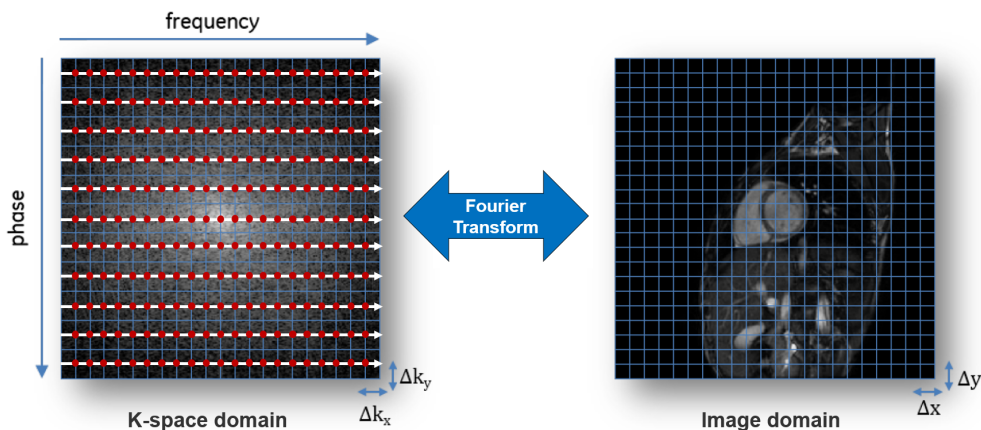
Data in k-space collected on a Cartesian grid (left) for cardiac MR imaging. The Fourier transform is used to transform the k-space samples to an image (right). The spacing between adjacent samples in k-space (Δk_x and Δk_y) is inversely proportional to the resolution in image space (Δx and Δy). (Image adapted from [29])
